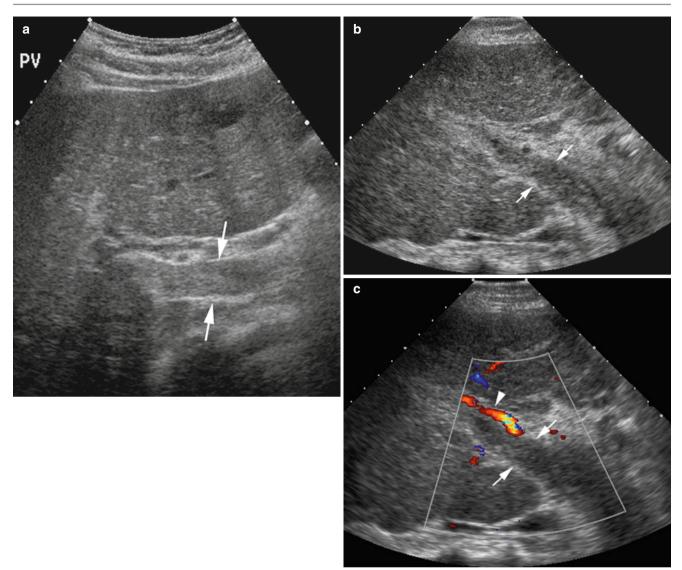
Portal vein thrombosis. (a, b) Sonograms of porta hepatis in two different patients showing the main portal vein (*arrows*) expanded and filled with echoes due to thrombosis. The echo texture of the liver in (b) is coarse and heterogeneous due to advanced
